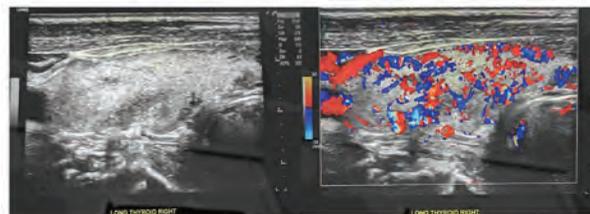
Transverse (a) sonographic and (b) Doppler ultrasound images of the thyroid gland showing diffuse echogenicity with increased vascularity, respectively.
